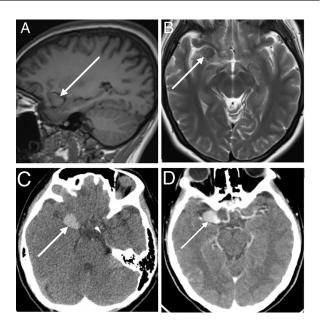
The right middle cerebral artery aneurysm contained an early subacute thrombus. (A) Slightly homogeneous hyperintensity on MRI-T1 (arrow). (B) Slightly homogeneous signal reduction on MRI-T2 (arrow). (C) Homogeneous enhancement on non-contrast CT (arrow).
